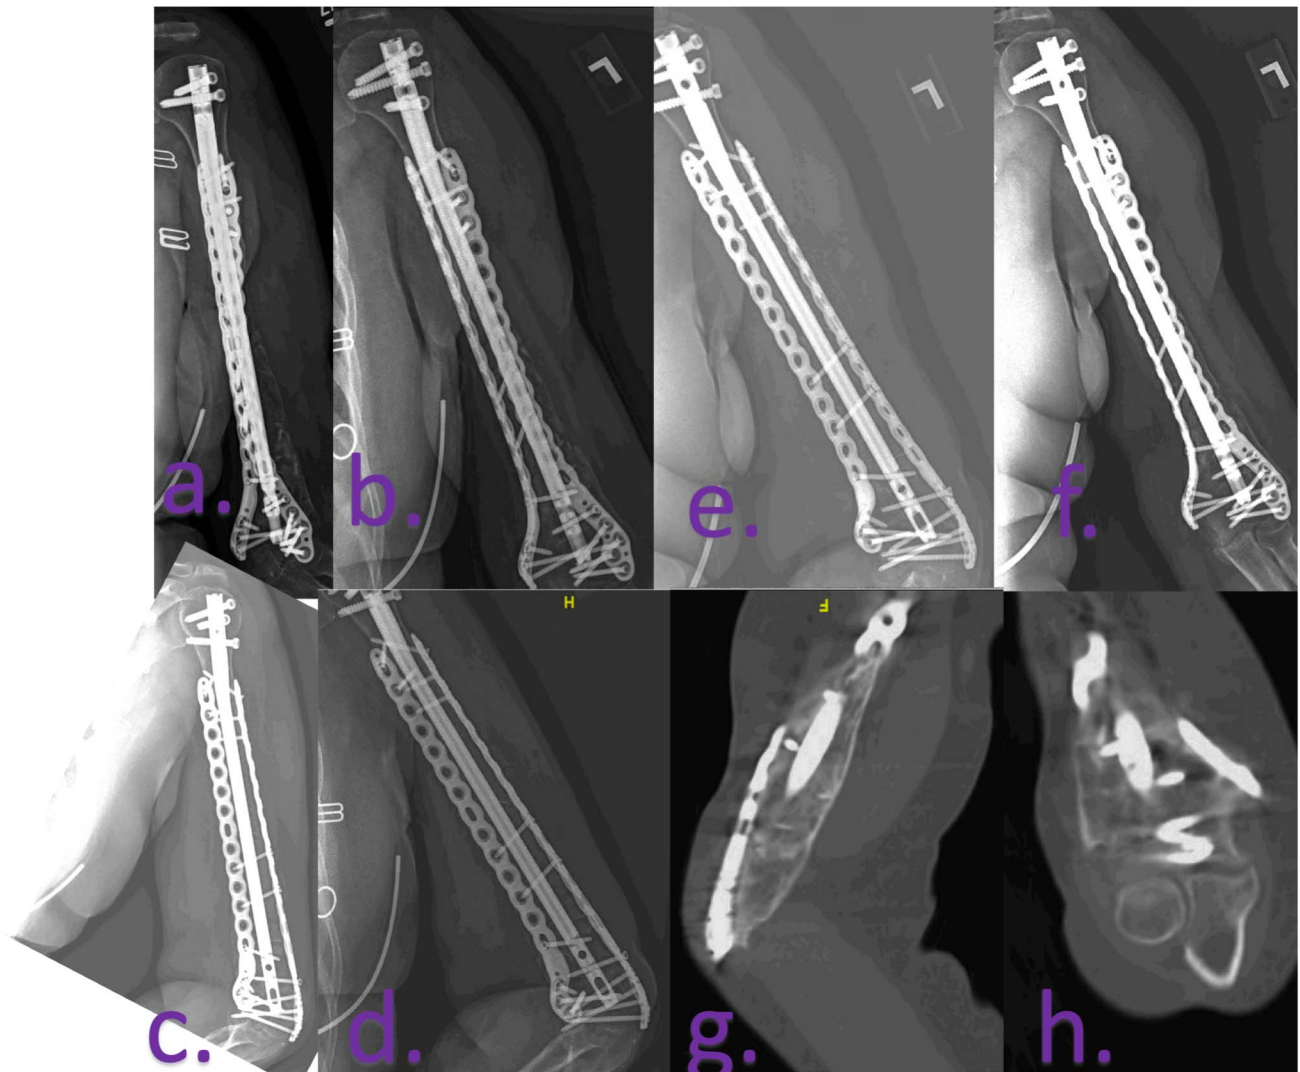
Postoperative radiographs after repeat bone grafting. Five months postoperative repeat bone grafting AP (A) and lateral (B) plain radiographs. 1 year postoperative repeat bone grafting AP (C) and lateral (D) plain radiographs. 2 years postoperative repeat bone grafting AP (E) and lateral (F) plain radiographs. Two years postoperative repeat bone grafting CT cuts (G and H).
